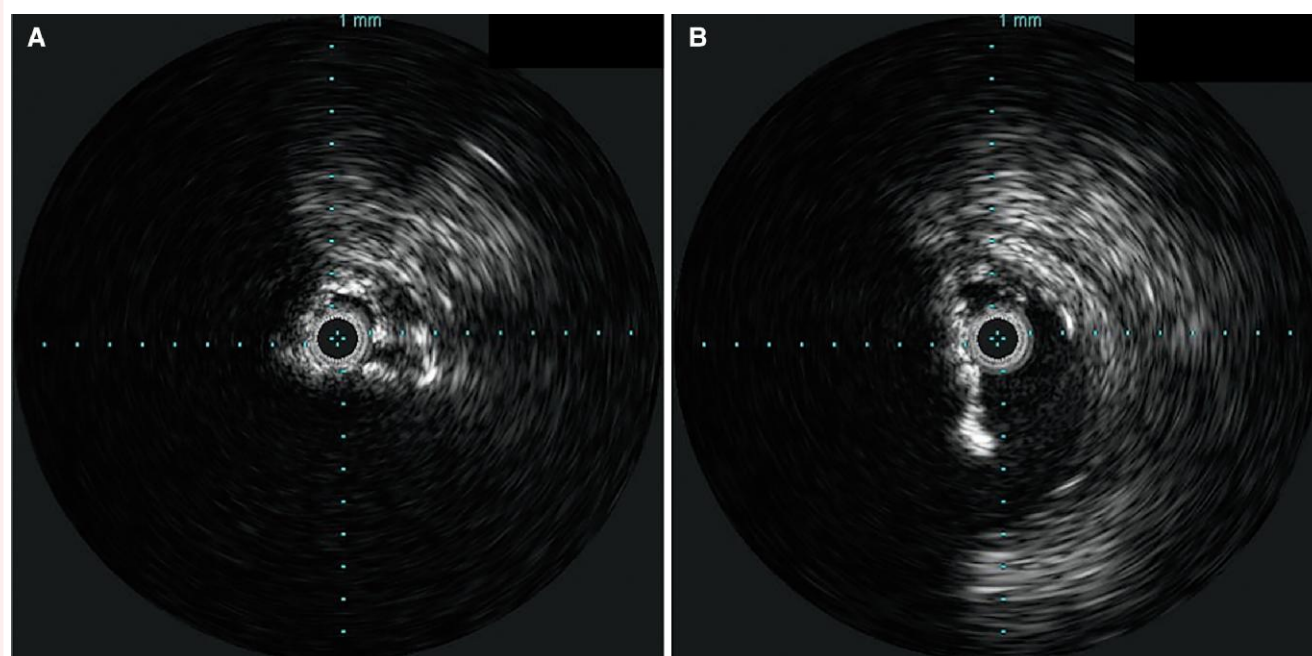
Intravascular ultrasound findings. (A) First intravascular ultrasound before dilatation showed more severe stenosis than in angiography, with circumferential calcification. The minimum lumen area was 8.9 mm^2 . (B) Final intravascular ultrasound showed that expansion was achieved, but that semiperipheral calcification remained. The minimum lumen area was 11.1 mm^2 .
